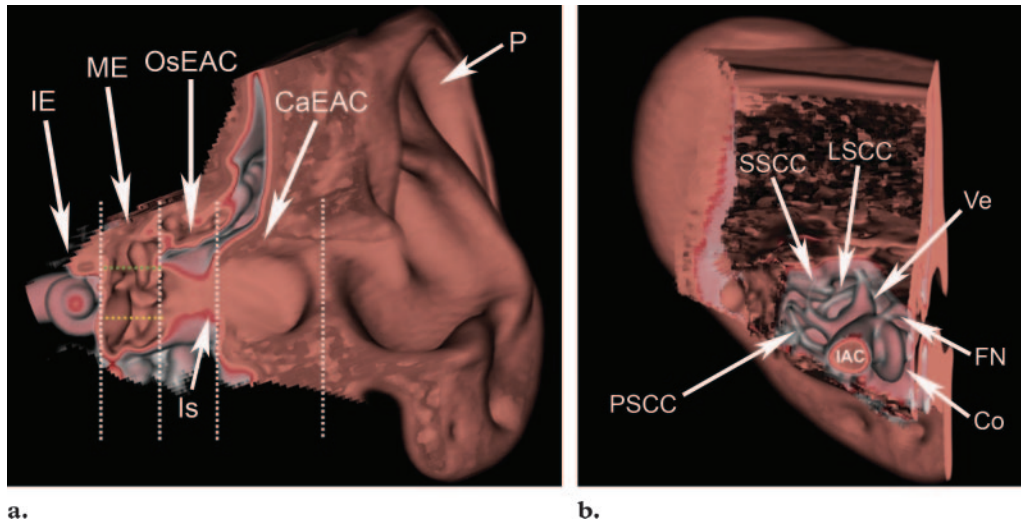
Normal anatomy of the auditory apparatus. (a) Oblique coronal 3D VR CT image (anterior view) shows the pinna (*P*); the EAC, including the cartilaginous (*CaEAC*) and osseous (*OsEAC*) portions; the isthmus (*Is*); the middle ear cavity (*ME*); and the inner ear (*IE*). The middle ear is divided into the epitympanum (above dotted green line), mesotympanum (between dotted green and dotted yellow lines), and hypotympanum (below dotted yellow line). (b) Three-dimensional VR CT image (view from the dissected medial portion of the temporal bone) shows the inner ear, including the cochlea (*Co*), vestibule (*Ve*), superior semicircular canal (*SSCC*), lateral semicircular canal (*LSCC*), and posterior semicircular canal (*PSCC*). The internal auditory canal (*IAC*) and the bony canal for the facial nerve (*FN*) are also seen.
